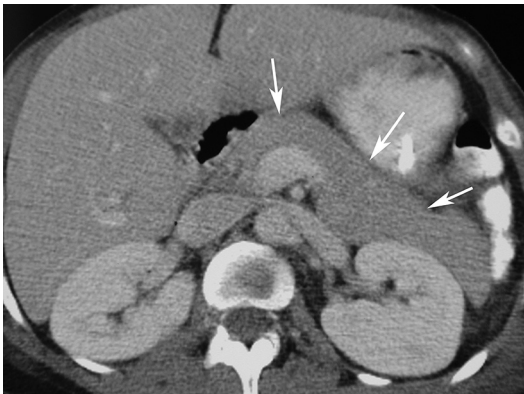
Acute interstitial edematous pancreatitis, CTSI 1. This 45-year-old man suffered from acute onset of epigastric pain for 12 hours. Acute pancreatitis was diagnosed based on the clinical presentation and elevated lipase and amylase levels. CT shows a slightly enlarged pancreas (arrows) without peripancreatic stranding.
